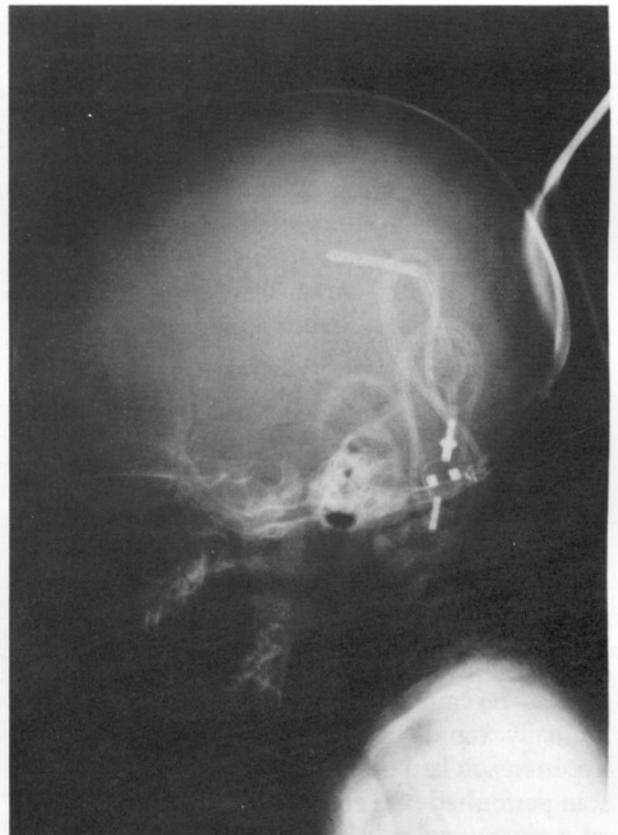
Skull X-Ray showing the migrated peritoneal catheter describing loops around the PAVS. The ventricular catheter remains normally positioned. (April 15th, 1992)
